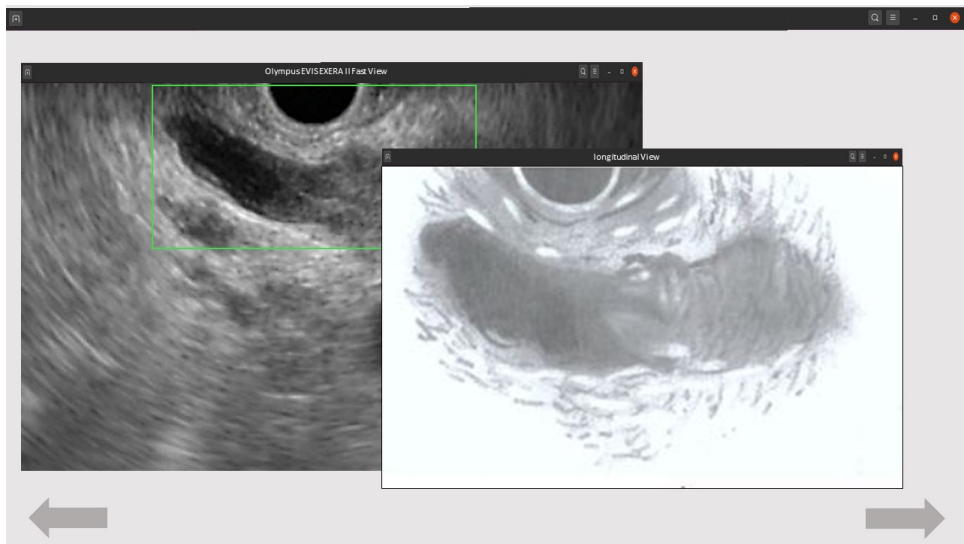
Endosonogram of a normal bile duct (see online version for colours)
